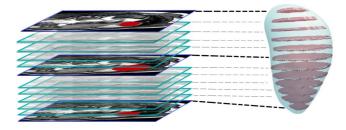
The LV (highlighted in red in the short axis images on the left) can be segmented from MR image data (a stack of 2D slices which make up a 3D volume). Such a segmentation represents the chamber's volume. For physicalization, this volume can be "sliced" into thin slabs (shown on the right), which provide a natural support structure for physicalization while also maintaining a sense of the data.
